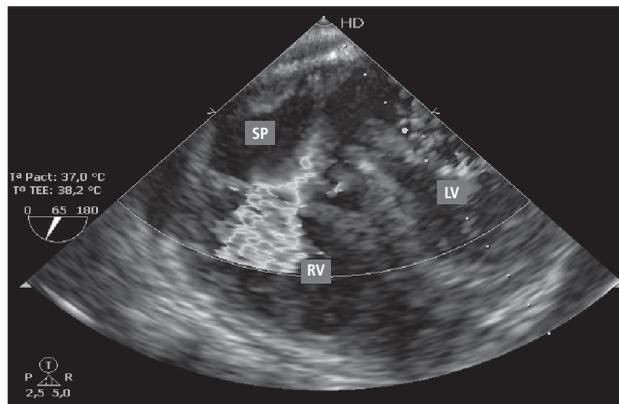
Intraoperative transesophageal echocardiography. Color Doppler. Left ventricular (LV) blood flow to septal pseudoaneurysm (SP) and from the SP to the right ventricle (RV) is identified.
